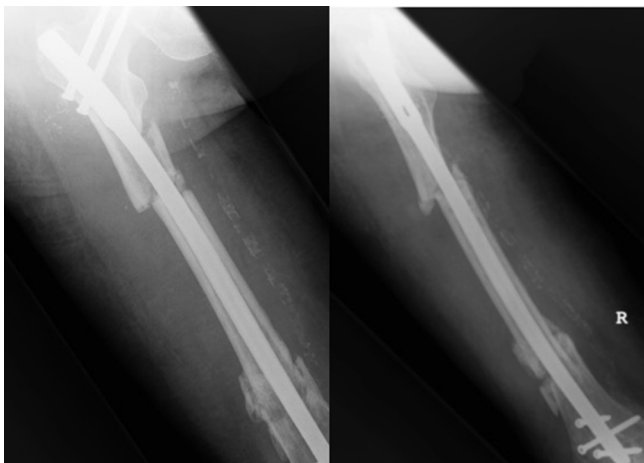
Radiographs in ap and lateral view show correct positioning of the nail, good reduction, and increasing consolidation of both fractures.
